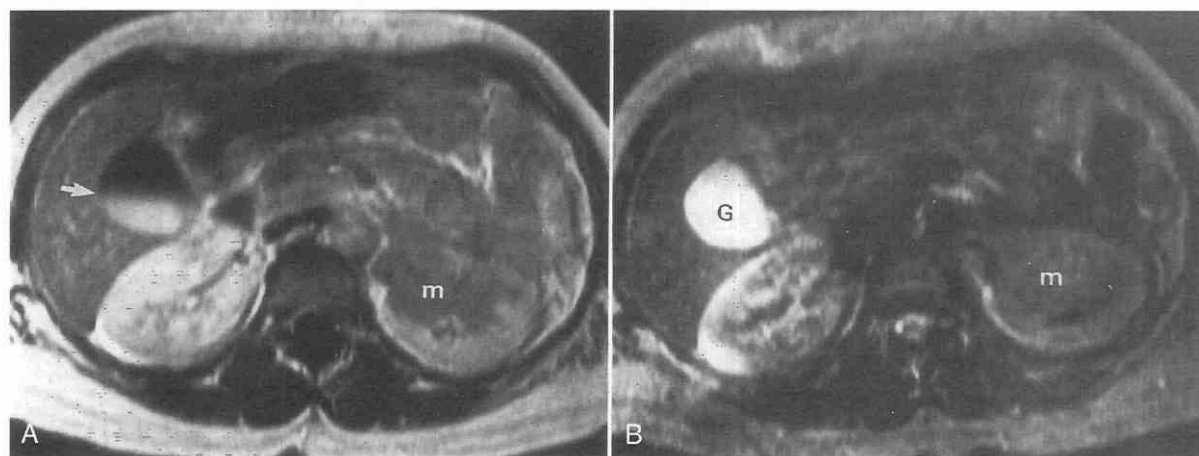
Layering bile in gallbladder. Note patient also has left renal neoplasm (m). A, T1-weighted image showing concentrated bile (hyperintense) layering dependently beneath the less concentrated bile (hypointense) in the gallbladder (white arrow). TR = 700; TE = 10. B, T2-weighted image showing all bile in gallbladder (G) turned hyperintense. TR = 2000; TE = 80.
